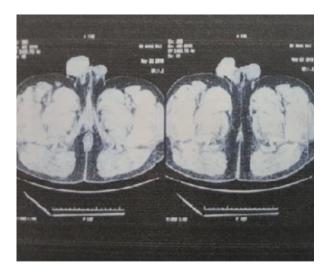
CT scan showing lesion in right testis.
